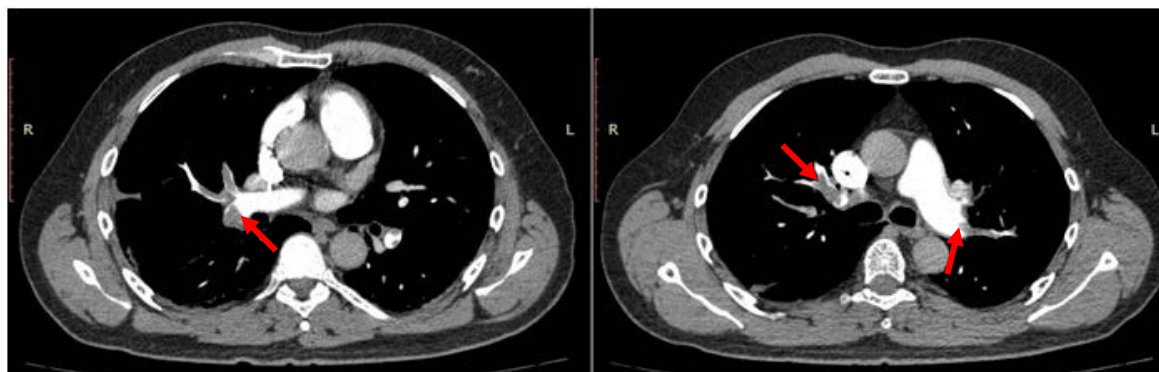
Computed tomography scan showing the presence of thrombi in the main pulmonary branches (red arrows).
